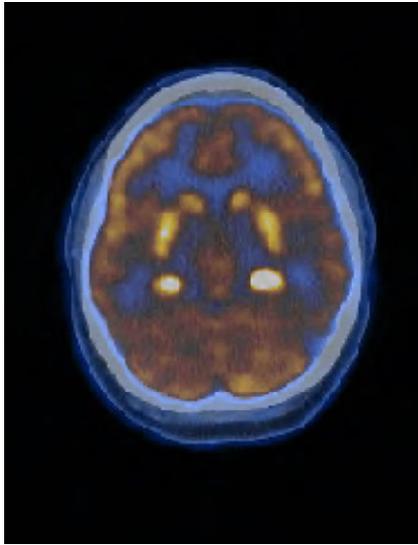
Cerebral PET scan, showing intense symmetric medial temporal lobe FDG activity.
